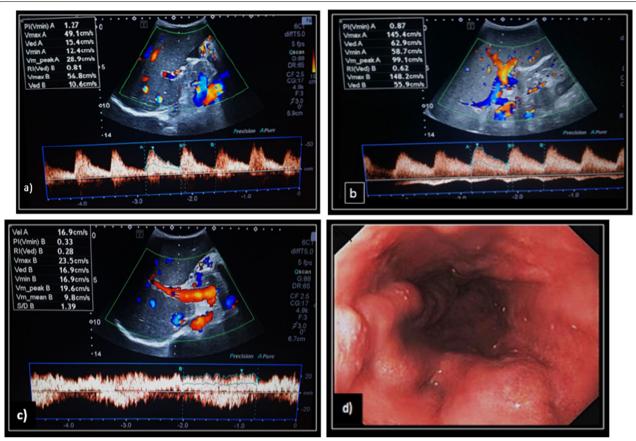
52 y male patient with chronic liver disease, a presents Doppler U/S of hepatic artery with HAPI: 1.27 and HARI: 0.81. b Presents Doppler U/S of splenic artery with SARI: 0.62, the splenic bipolar diameter is 18 cm. c Presents Doppler U/S of PV with MVPV: 19.6 cm/s. PV diameter is 14 mm. ascites was also noticed. d UGIE revealed grade III oesophageal varices.
